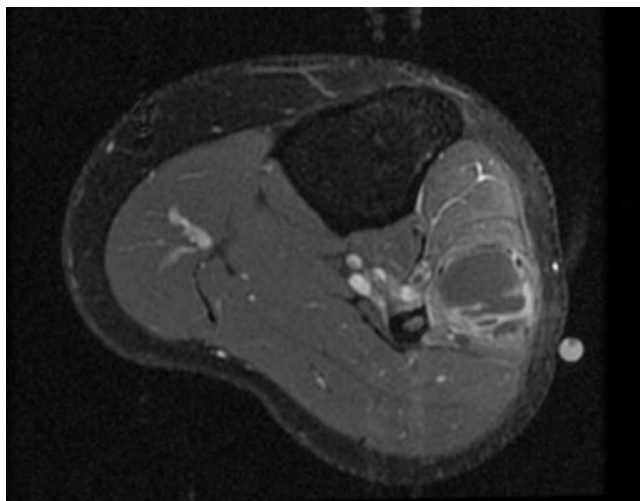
Ruptured peroneal ganglion cyst. Post-gadolinium T1 fat-saturated axial MRI shows enhancement of the cyst walls but not of the cyst contents or the surrounding tissues.
